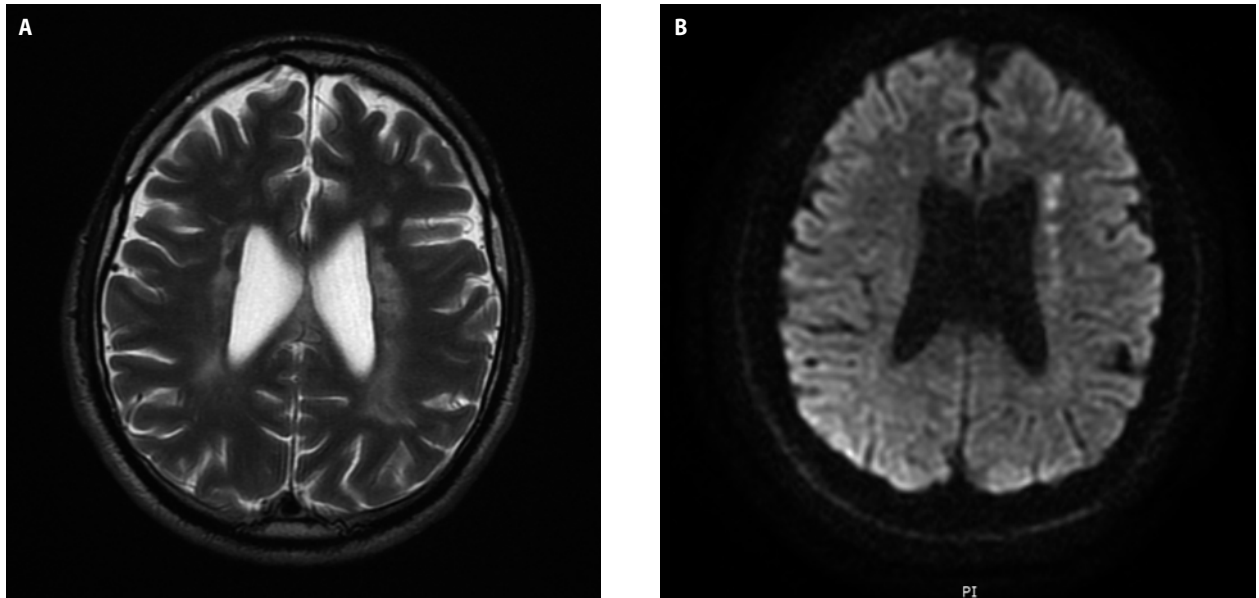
A. Magnetic resonance T2 imaging. Extensive, multifocal signal abnormalities in periventricular and deep white matter. Lateral ventricles and spaces are enlarged; B. Diffusion-weighted magnetic resonance images reveal multiple foci of diffusion restriction
